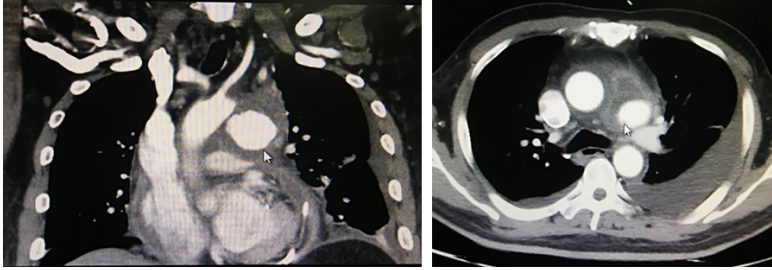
Computed tomography angiography (CTA) displays pseudoaneurysm of the aortic arch. Cystic bulge is seen in the local aortic arch. Contrast agent is found in the cystic bulge, and annular low-density shadows are observed surrounding the cystic bulge.
